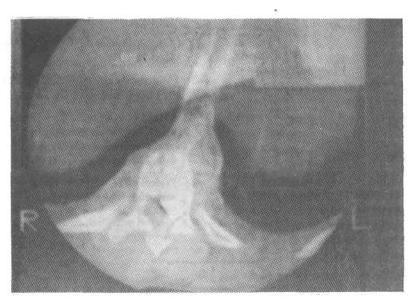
CT myelogram of dorsal spine showing extradural mass with compression of cord.
